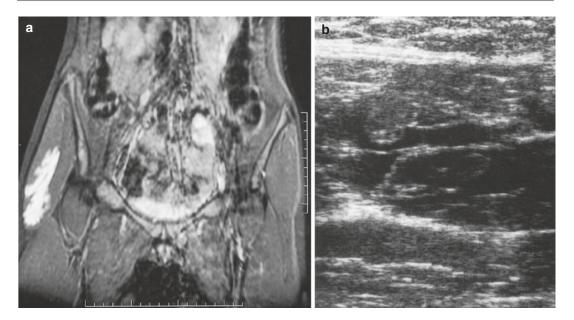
(a, b) Lymphangioma of right gluteus maximus. The patient complained of swelling of right buttock/ thigh when seated. (a) Coronal gradient-echo MR image.
